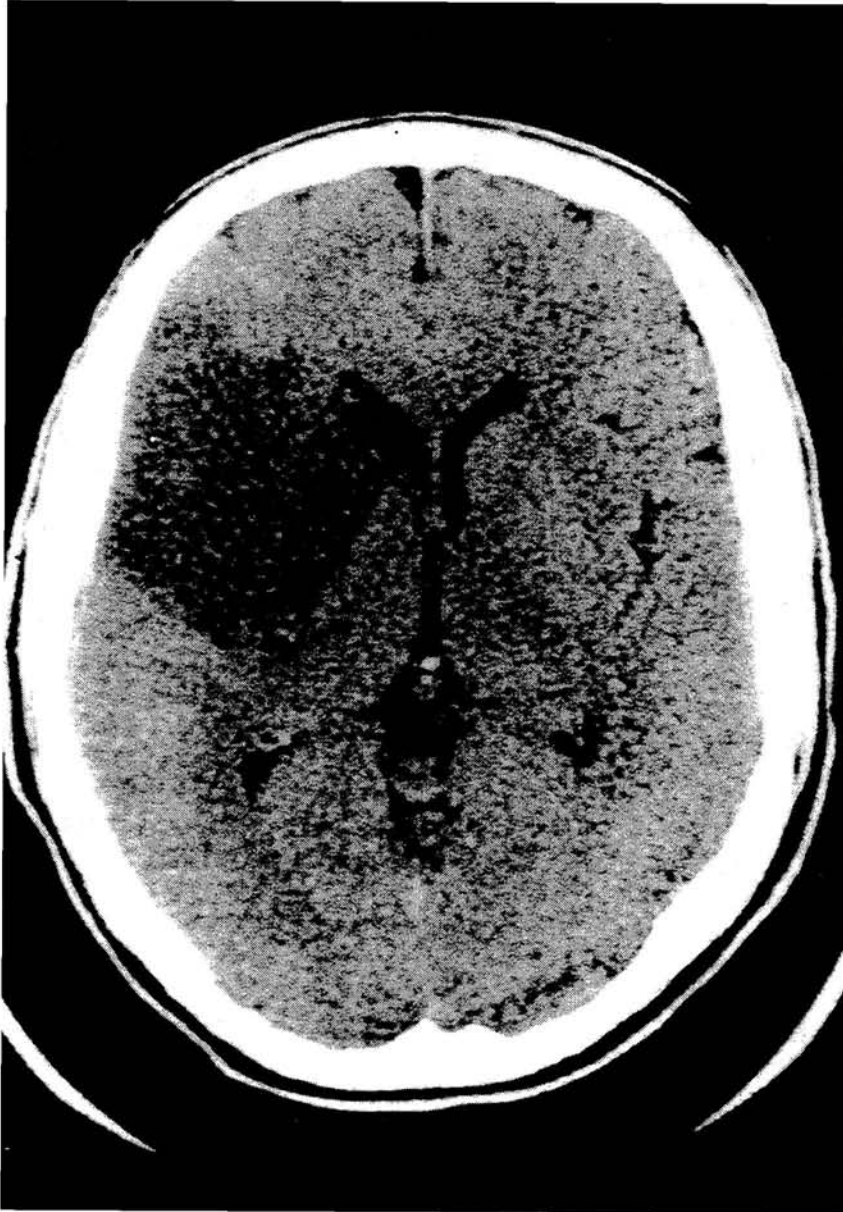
CT scan of patient C.D.
